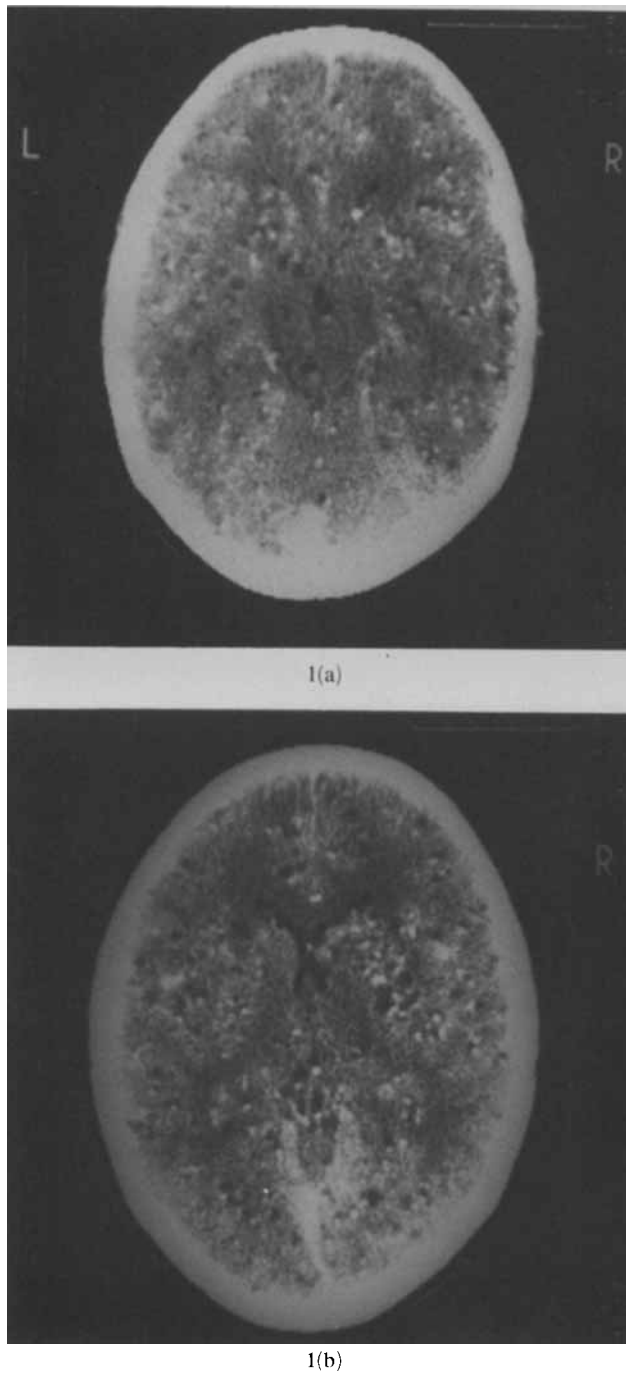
CT scan before treatment. A large number of cysticerci are observed, not only in the cortex, but also in the subcortical structures.
